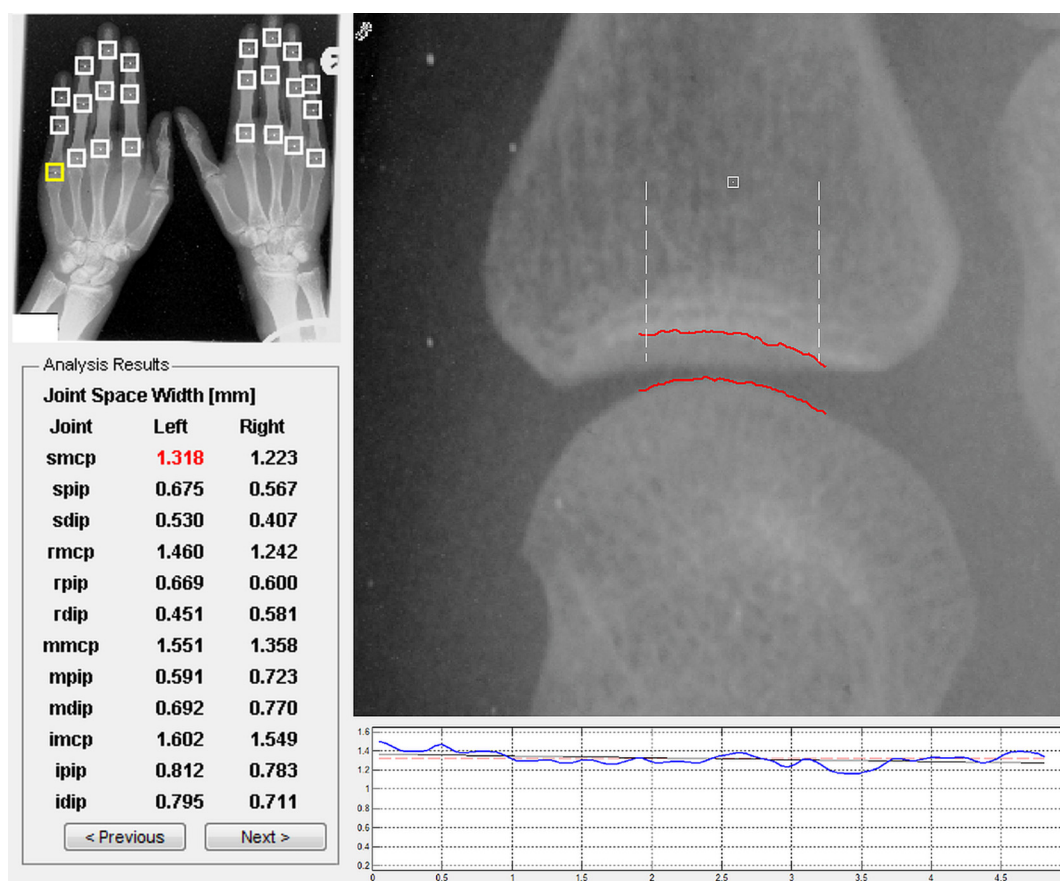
Automated image analysis of JSW of both hands on a screenshot of the user interface of the JAQ-program. In this step of the automated joint analysis, the user is able to adjust the detected contours by adding support points. The side panel shows the original hand radiograph, where the finger joint locations have been detected automatically. By selecting a joint in this image (small yellow rectangle), a close-up of the joint is presented in the main panel. The vertical dotted lines in the main panel indicate a standardized measurement area. After each optional adjustment, the calculated mean JSW is updated. The graph on the bottom shows the individual distances as a function of the horizontal position within the joint. Figure 6 can be viewed online in color at www.investigativeradiology.com.
